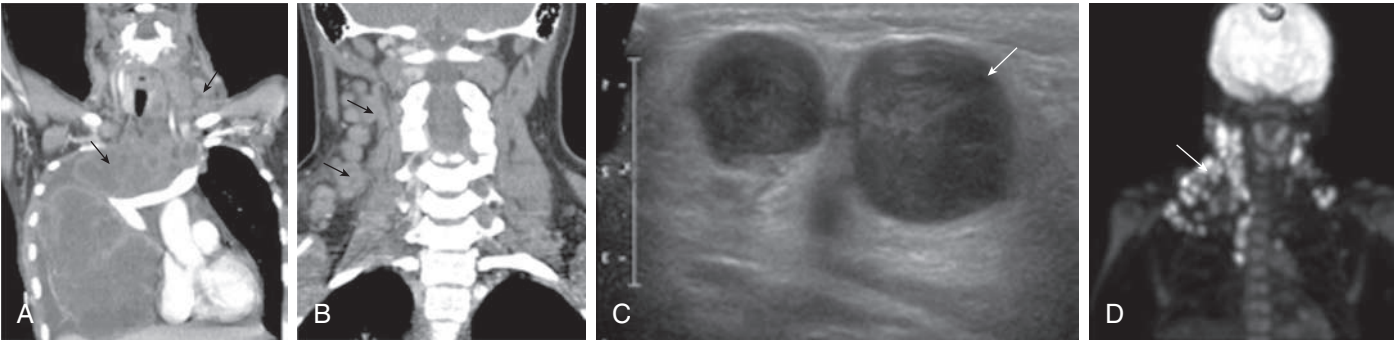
Lymphoma. Coronal postcontrast CT images demonstrate extensive cervical (A) and mediastinal (B) lymphadenopathy (arrows). C, Sonographic image demonstrates two enlarged lymph nodes with abnormal internal morphology (arrow). D, PET scan demonstrates metabolically active conglomeration of right-sided cervical lymph nodes (arrow). (From Haaga JR, Boll DT, et al., eds. *CT and MRI of the Whole Body* (Vol. 1). Philadelphia: Elsevier; 2017: Fig. 26-15, p. 768.)
